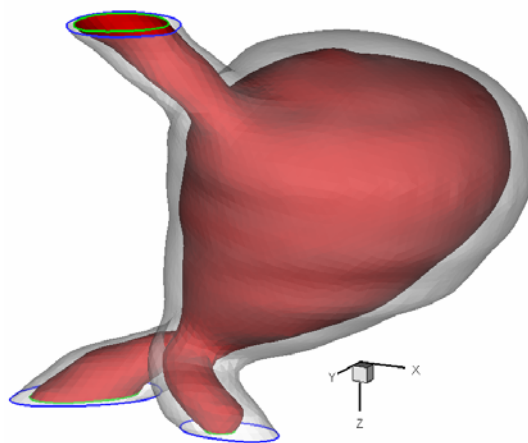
Internal (red) and external (grey-translucent) 3D reconstructed smoothed surfaces of the CT image extracted AAA geometry.
